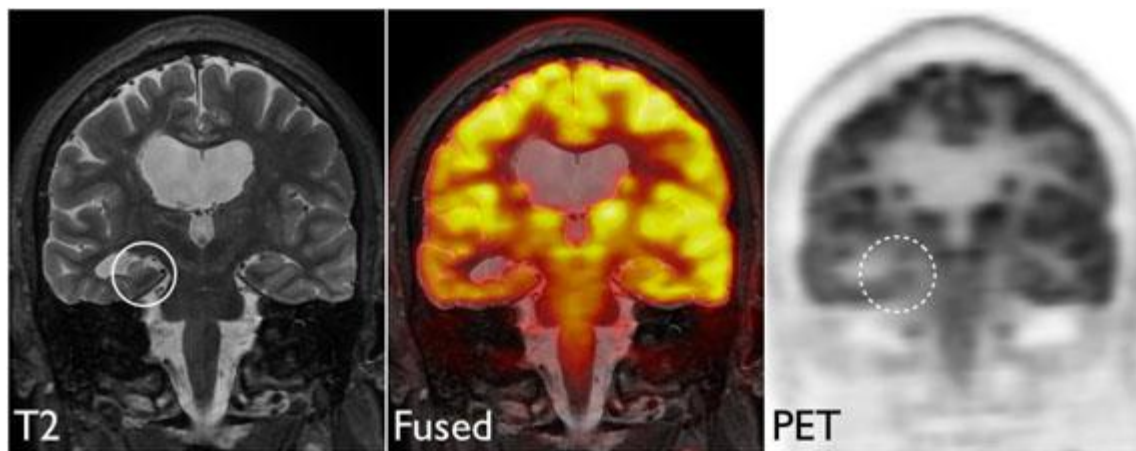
PET/MRI in a patient demonstrating volume loss in the right hippocampus (left, solid circle) with associated decreased metabolism seen on PET (right, dotted circle).
